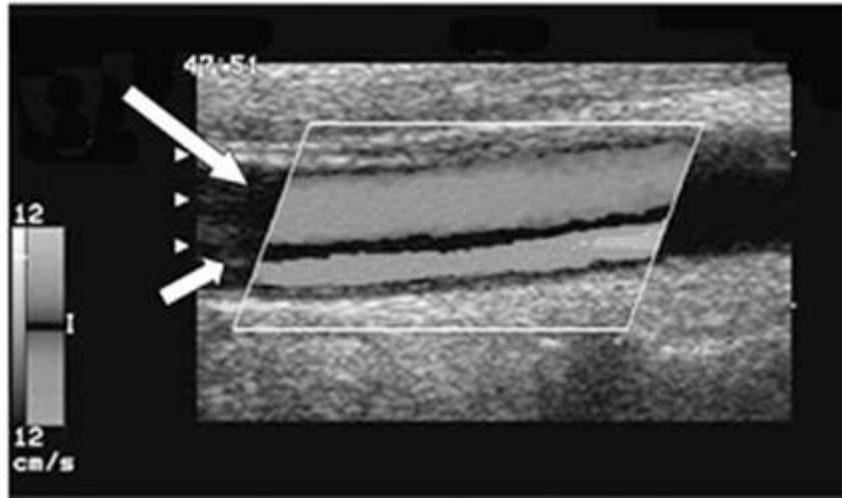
Carotid ultrasound reveals a patient with a carotid artery dissection in which carotid flow is separated in the true flow lumen (*long arrow*) from the false lumen (*short arrow*).
